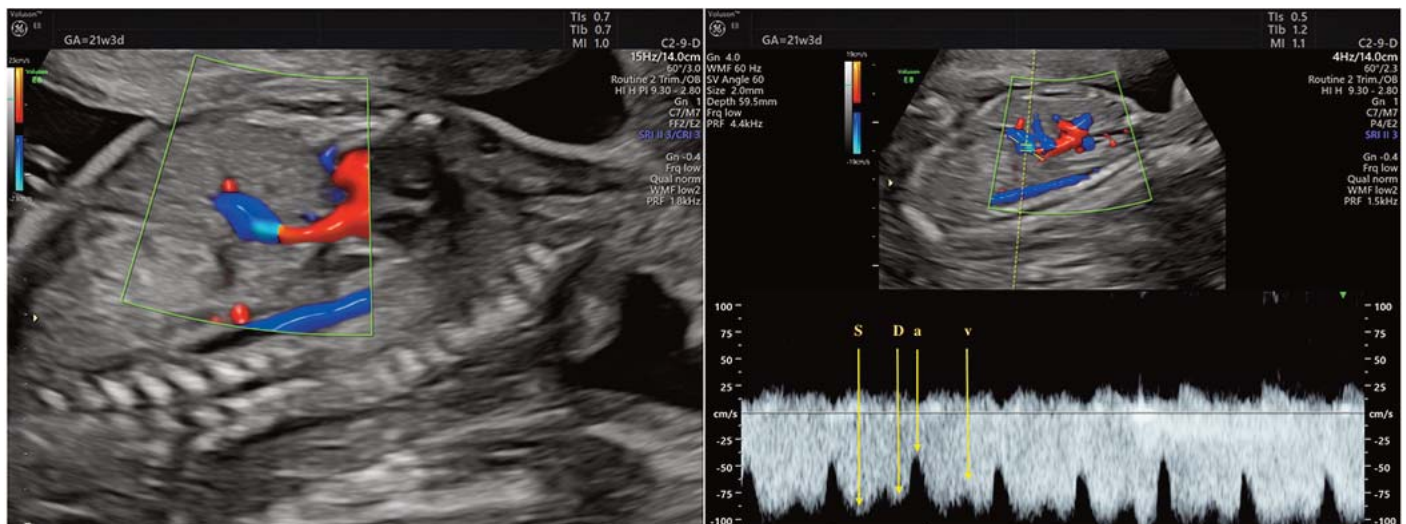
Ultrasound images demonstrating ductus venosus Doppler assessment at 21 weeks and 3 days of gestation.
